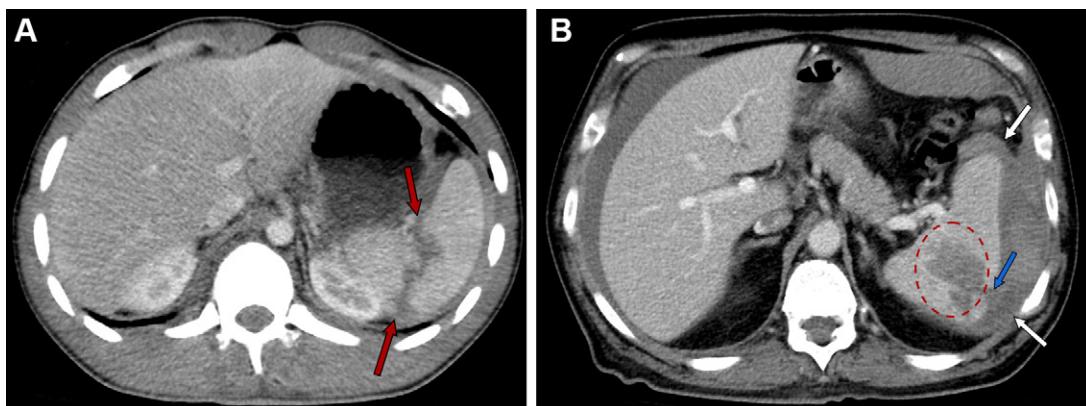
Grade III splenic injuries according to the revised 2018 AAST-OIS. (A) Axial contrast-enhanced CT image in a 37-year-old man after a high-speed motor vehicle collision shows an approximately 6-cm splenic laceration (arrows). Trabecular vessel involvement has been removed as a requirement for lacerations, making size the only requirement for distinguishing between grade II (1–3 cm) and III (>3 cm) injuries in the revised 2018 AAST-OIS version. The patient underwent splenic artery angiography, which revealed active extravasation from a superior splenic branch, which was embolized with coils. Given the high-grade nature of the laceration, the mid splenic artery was empirically embolized with an 8-mm Amplatzer Vascular Plug Version 2 (Abbott). An axial cine clip of this patient is shown in Movie 3. (B) Axial contrast-enhanced CT image in a 45-year-old man after a motor vehicle collision shows an intraparenchymal splenic hematoma (red circle), which communicates (blue arrow) with a large subcapsular splenic hematoma (white arrows) spanning over 50% of the splenic surface area. The subcapsular hematoma has ruptured, and there is blood extending to the peritoneum. The patient underwent angiography, which revealed no significant active extravasation or contained vascular injuries at the time of the procedure. The mid splenic artery was empirically embolized with Concerto coils (Medtronic) and one Azur coil (Terumo) with good angiographic results. The patient made a full recovery.
